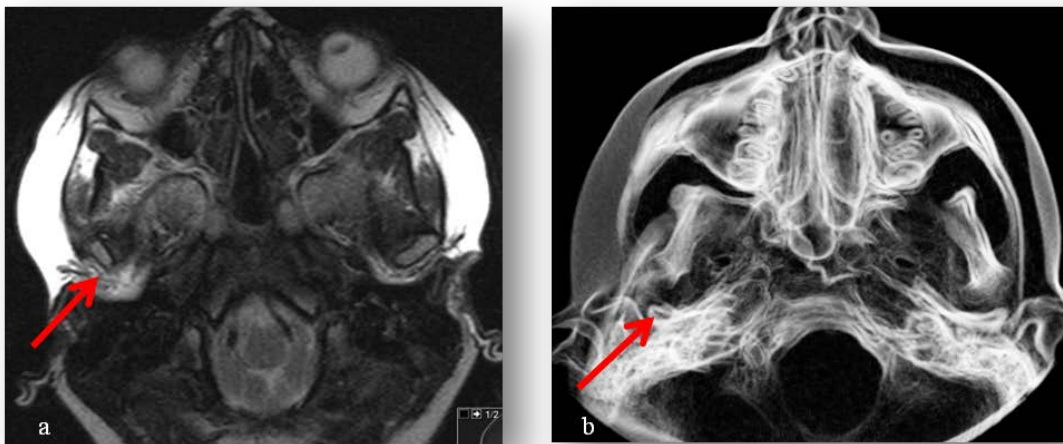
MRI and CBCT from a patient of figure 4. a) It is seen that the left condyle is smaller in the latero-medial direction. In a close mouth position it is not possible to observe the disk position in this left condyle. The condyle is normal in the right joint. Note the presence of synovial enhancement on the corresponding axial fat-saturated postgadolinium T1-weighted image of both TMJ, but remarkable in the left one. b) CBCT view.
